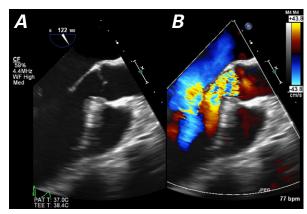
Transesophageal echocardiograms show severe aortic regurgitation in A) 2-dimensional midesophageal long-axis view and B) color-Doppler mode.
